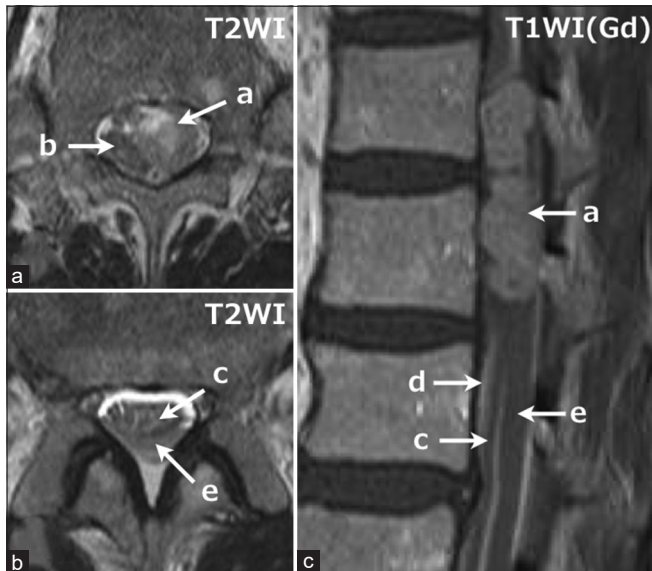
Axial images of T2-weighted MRI at the level of L1 (a) and L2 (b), and sagittal image of Gd-enhanced T1-weighted MRI (c). The tumor mass (a) markedly compressed the conus medullaris (b) to the right side. The subarachnoid space around the cauda equina (c) just caudal to the tumor mass (a) is densely filled with clots (d), and there is a thick subdural hematoma (e) dorsal to the cauda equina.
